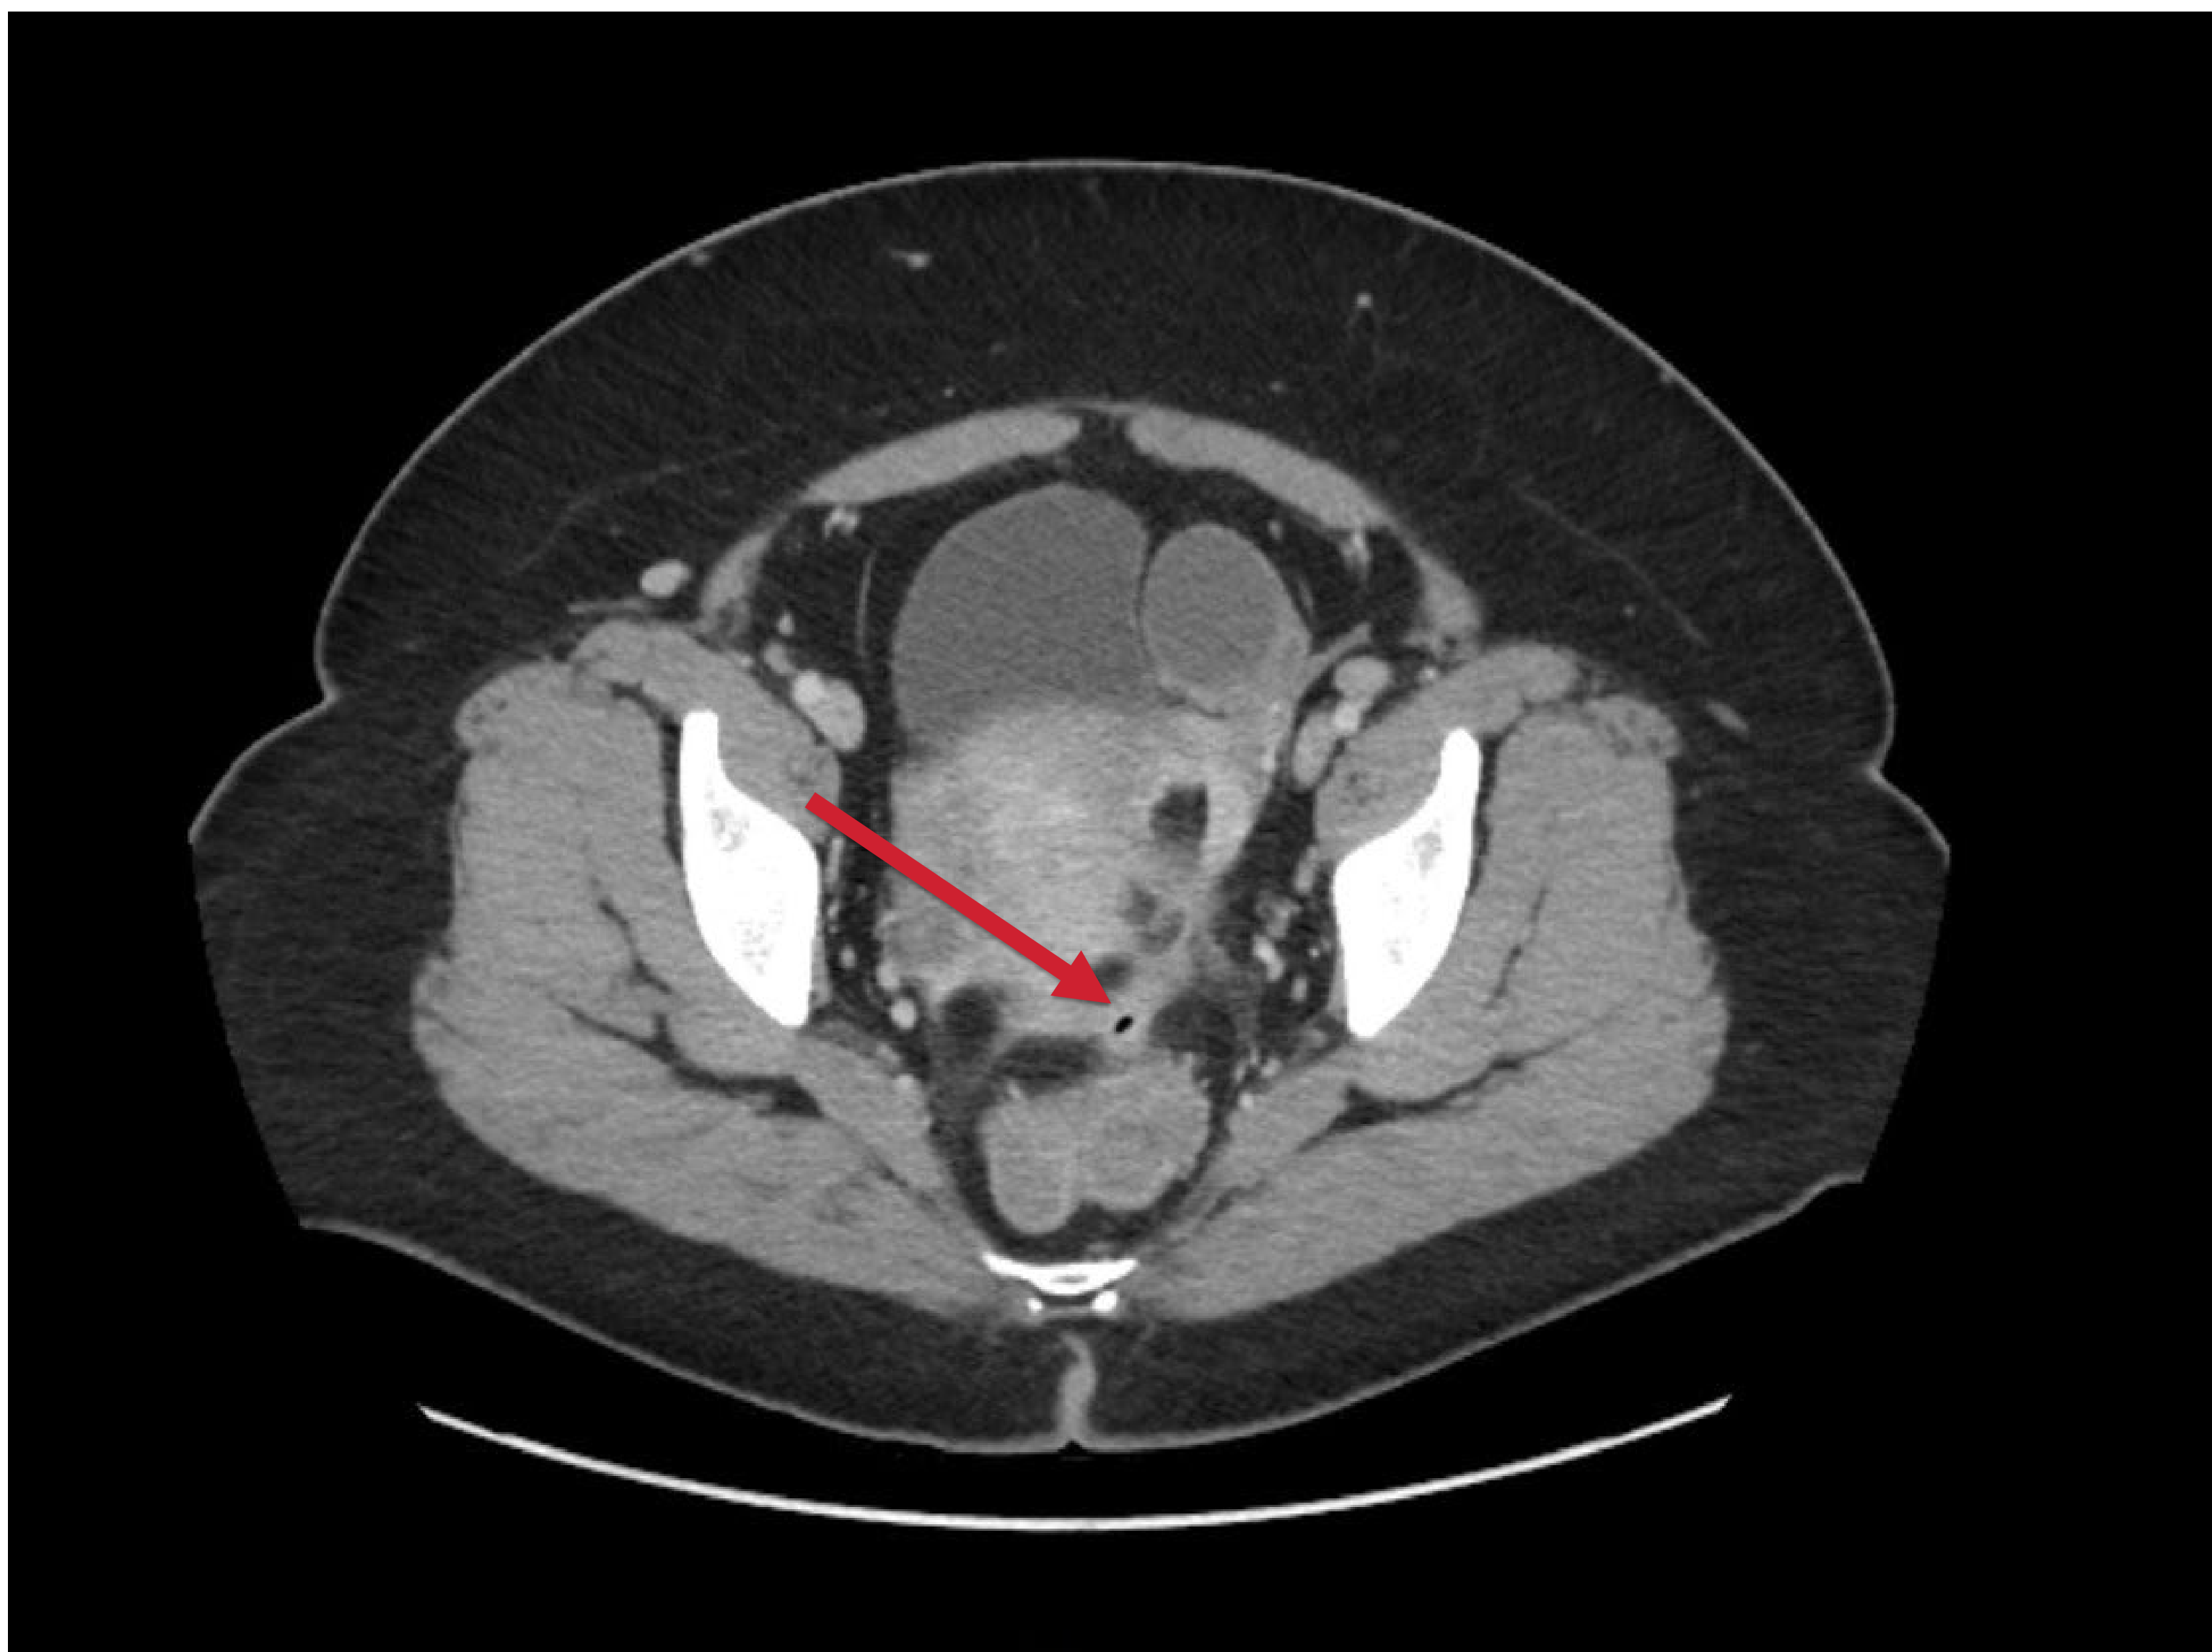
CT scan demonstrating fistulous connection between the patient's sigmoid colon and vaginal fornix
